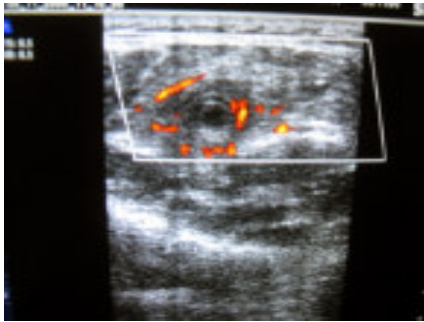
Intramuscular cysticercosis with peripheral inflammation. Color doppler showing increased vascularity
